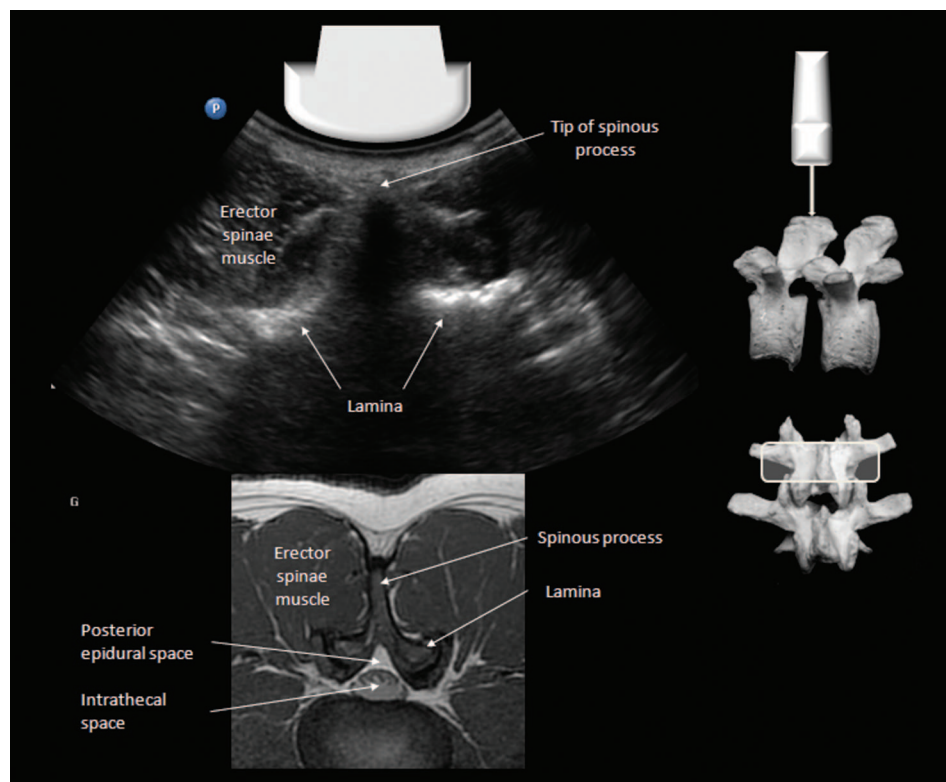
Transverse spinous process view of the lumbar spine and corresponding magnetic resonance imaging scan (T1-weighted). The tip of the spinous process and the lamina are brightly hyperechoic on ultrasound with pronounced acoustic shadowing that obscures all deeper structures. (Image used with permission from www.usra.ca.)
